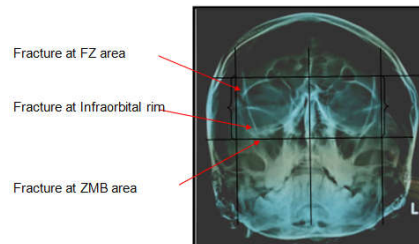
Showing preoperative radiograph
